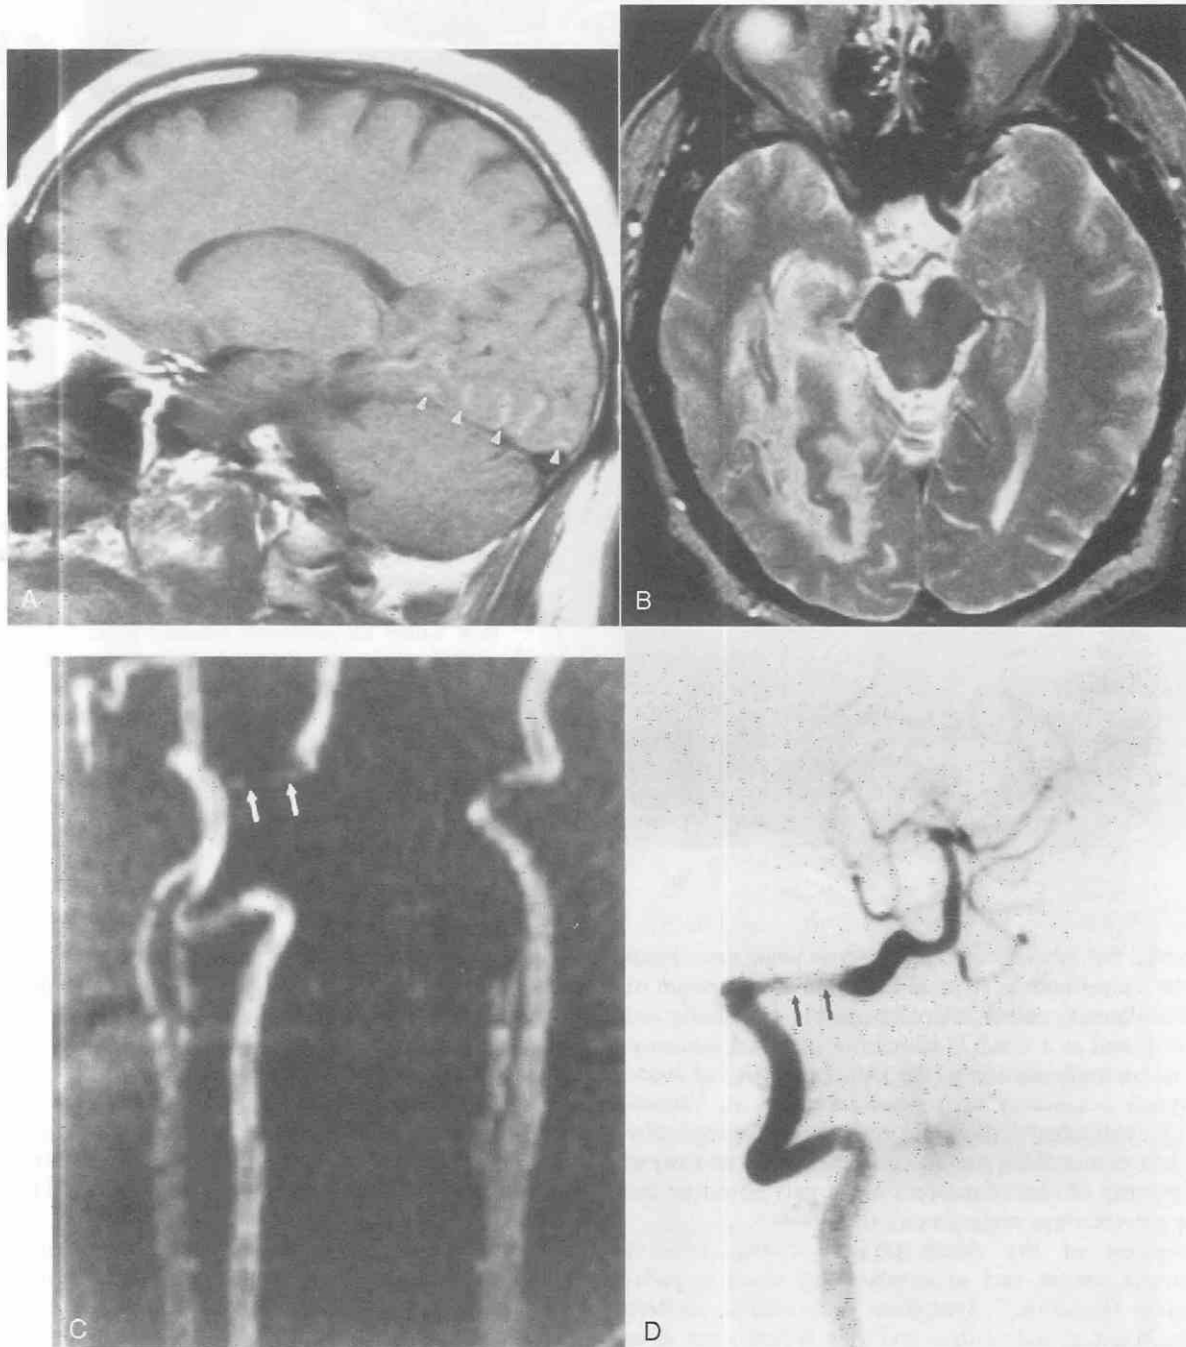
A, Arterial dissection. Sagittal T1-weighted (500/15) MR image shows cortical ribbon of hyperintensity representing subacute hemorrhage in the right temporal lobe (arrowheads). B, Hyperintense signal is evident on axial T2-weighted (2500/80) image. Findings are consistent with acute infarction. C, Two-dimensional time-of-flight MR angiography study demonstrates irregular narrowing of the right vertebral artery consistent with dissection (arrows). D, Intraarterial digital subtraction angiogram of the right vertebral artery confirms the dissection (arrows).
